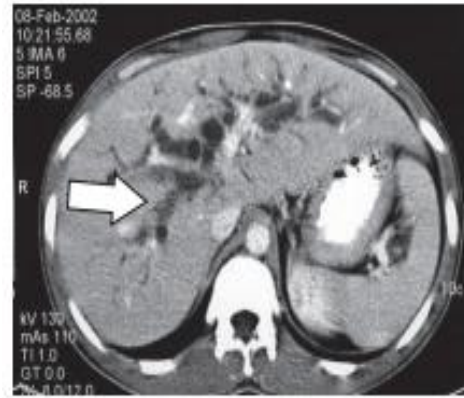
CT scan showing dilated bile ducts (arrow).
